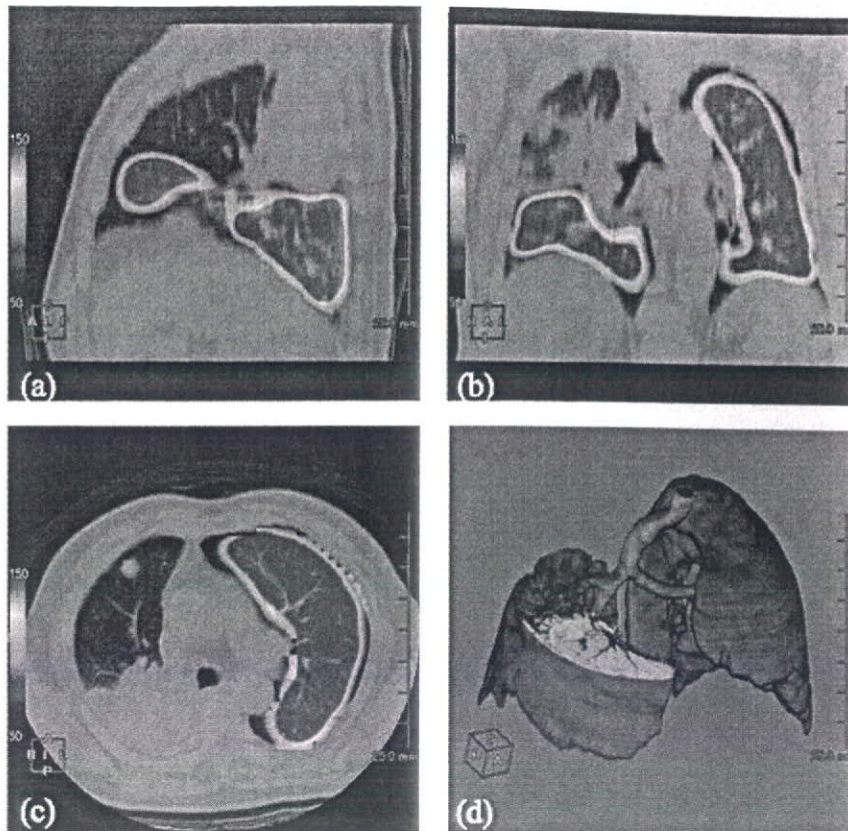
SPECT/CT of the same slices in Fig. 1. The right upper lobe outside of the tumor and atelectasis showed poor perfusion. (a) sagittal; (b) coronal; (c) axial; and (d) 3D imaging after virtual lobectomy.
